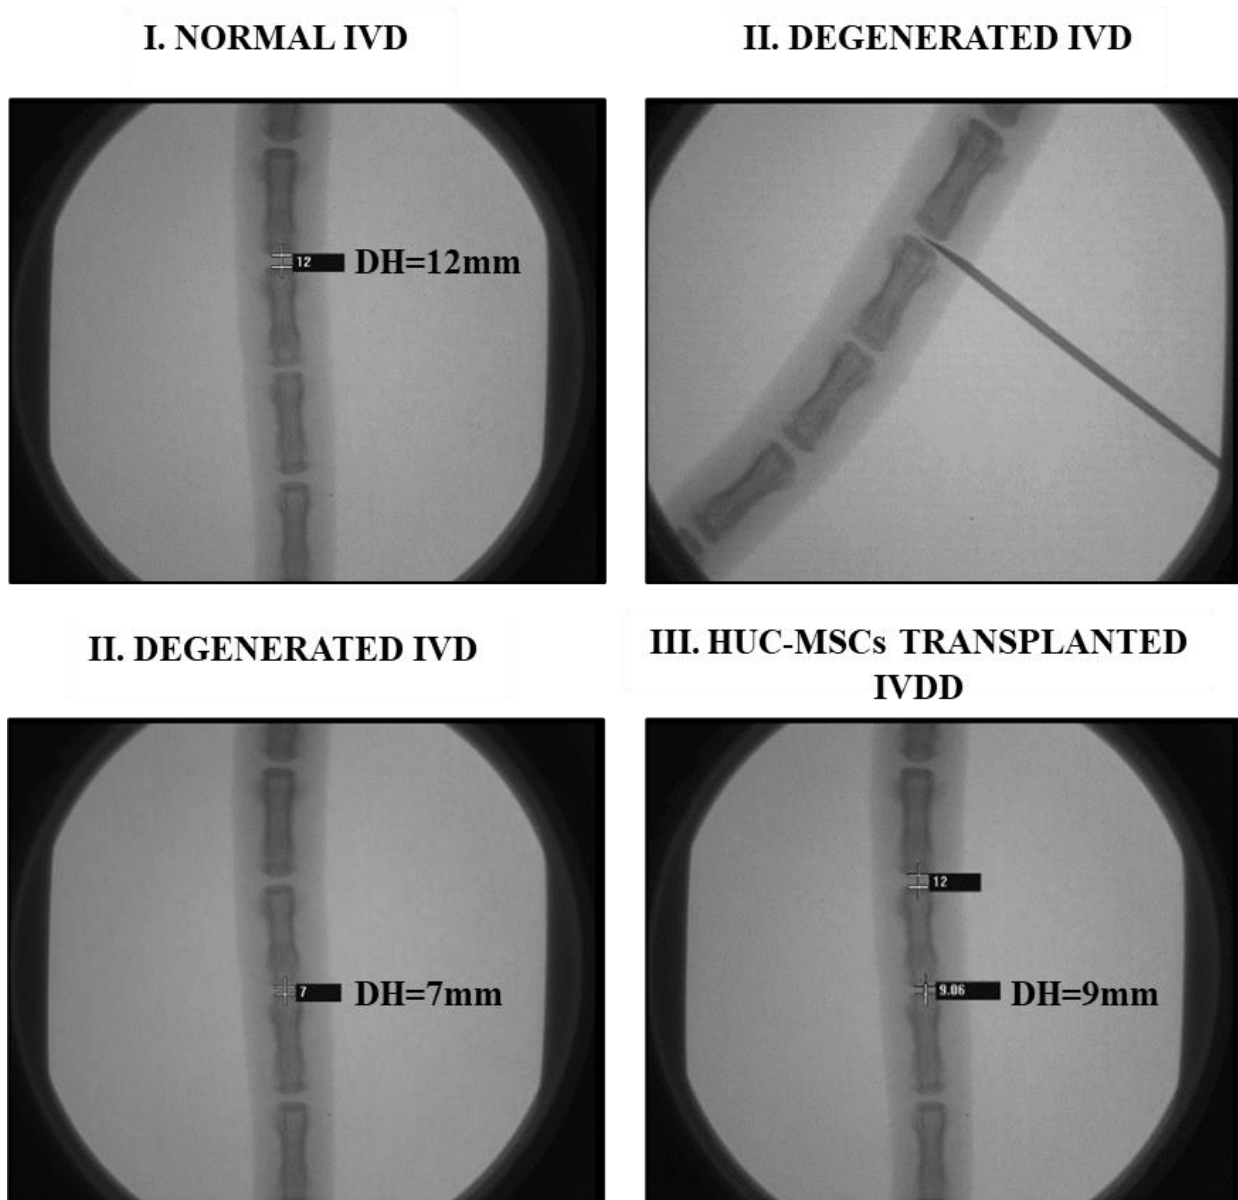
IVD X-Ray Fluoroscopic Visualization and Disc Height: I. Disc height of normal IVD [C0 5/6] is 12 mm. II. IVDD model by needle injection to puncture IVD [C0 6/7]. IVDD model [Co 6/7] showing the least disc height 7 mm. III. Degenerated IVD [Co 6/7] are injected with autologous MSCs for 2-week increased disc height by 9 mm as compared to the IVDD model 7 mm.
